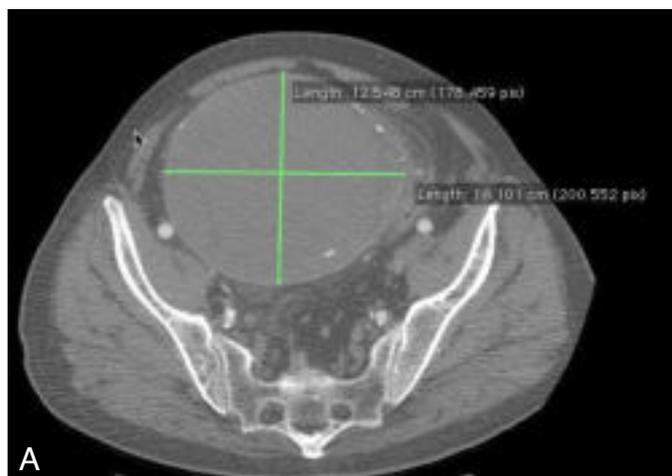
Contrast-enhanced axial computed tomography examination shows the transversal diameter of the giant right common iliac artery of 14.1 centimeters.
